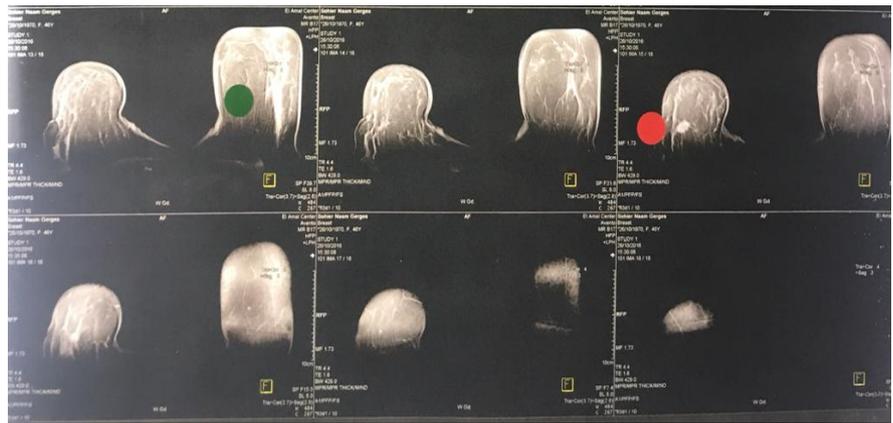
MRI breast showing breast mass the pathology reveal infiltrating duct carcinoma.
